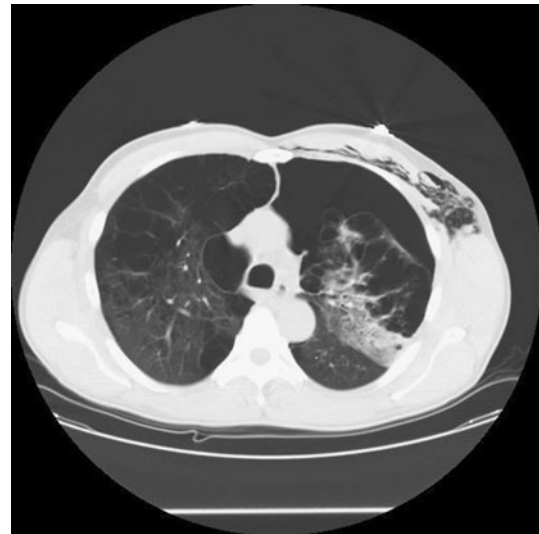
Figure Thoracic computed tomography (CT) scan of patient demonstrating bilateral bullae, emphysema, and left-sided pneumothorax
